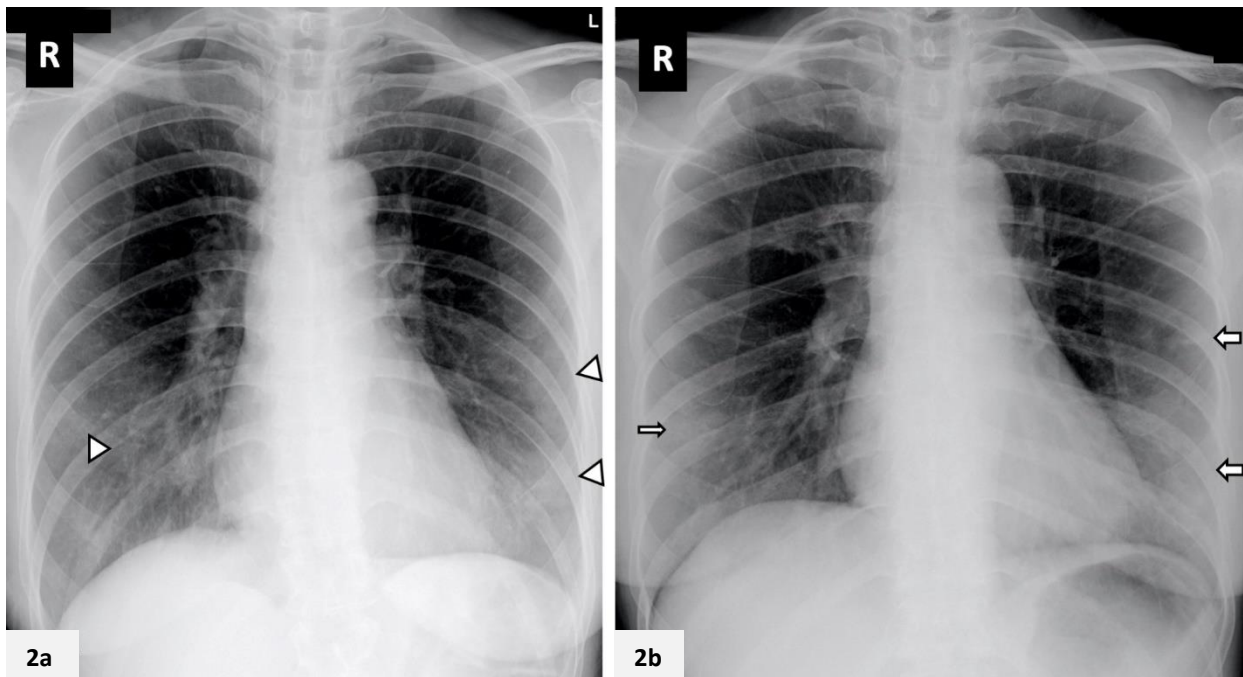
A 55-year-old woman with fever, cough and dyspnoea for 4 days. (a) Initial chest radiograph obtained on Day 4 of symptoms shows multifocal ground-glass opacities in the bilateral lower zones (arrowheads). (b) Follow-up radiograph performed 2 days later shows increased density in the left lower zone (broad arrows), in keeping with consolidation. A small focus of consolidation is also seen in the right lower zone (thin arrow).
